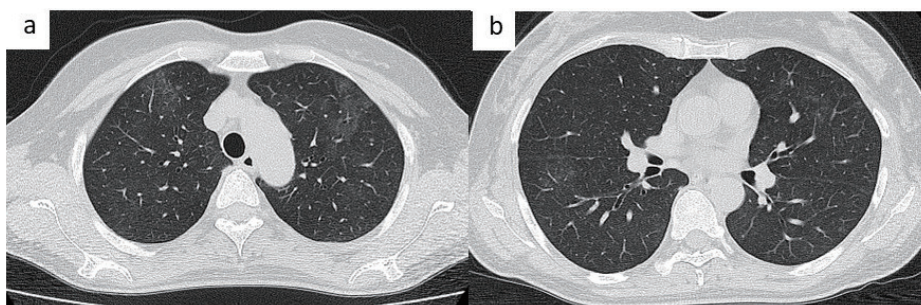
a, b: Chest CT shows diffuse dominant ground-glass opacities over bilateral upper lobes of the lungs
